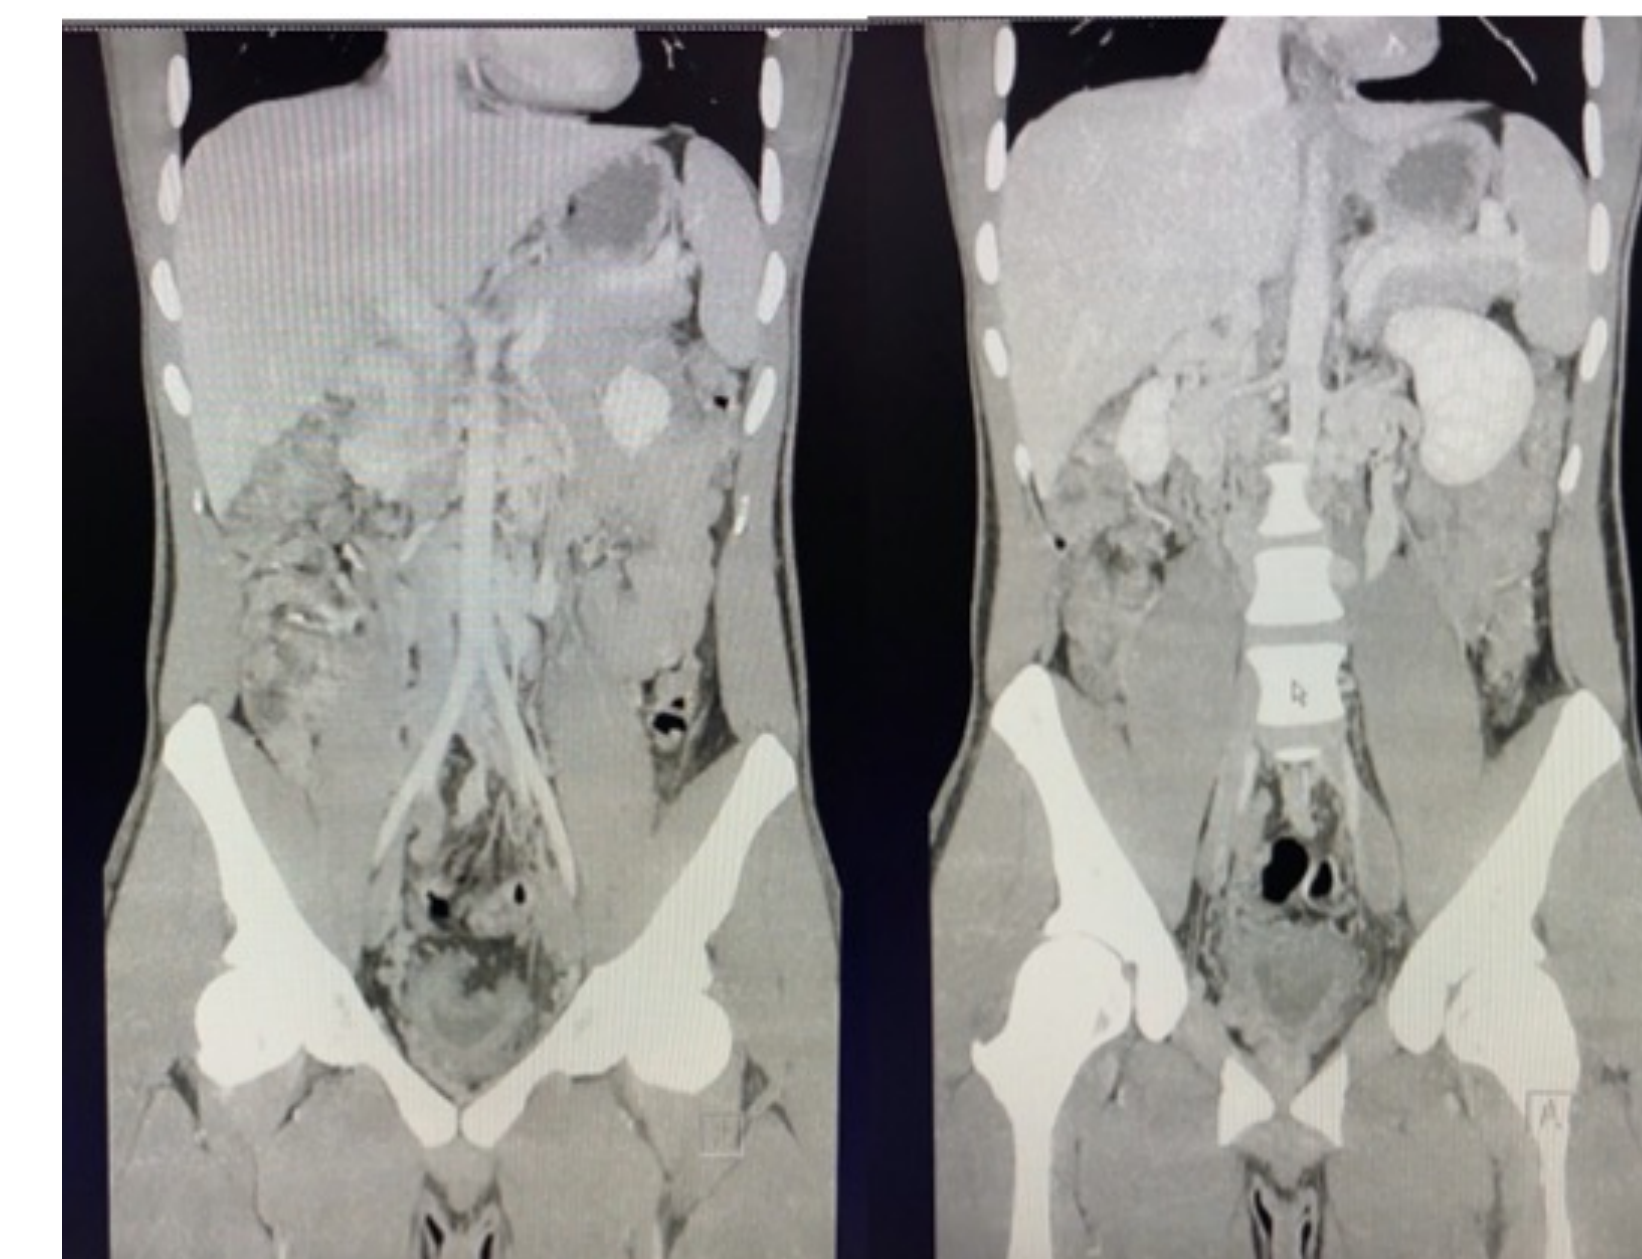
This coronal view of the CT venogram also demonstrates the abdominal aorta and the infrarenal inferior vena cava. As can be seen, there is no discernible suprarenal inferior vena cava.
